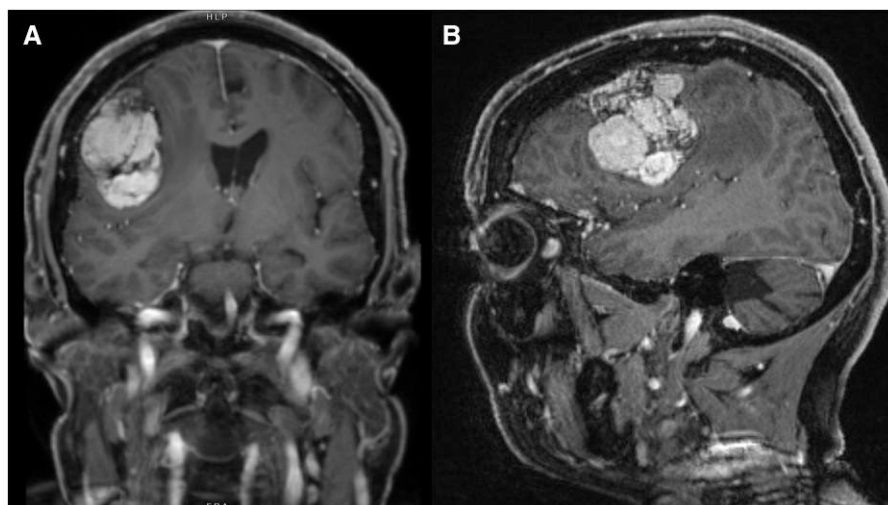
MRI brain demonstrating multiple right frontal lobe meningiomas (including one giant meningioma) with adjacent vasogenic edema and midline shift. A, Coronal view (T1-weighted); B, Sagittal view (T1-weighted).
